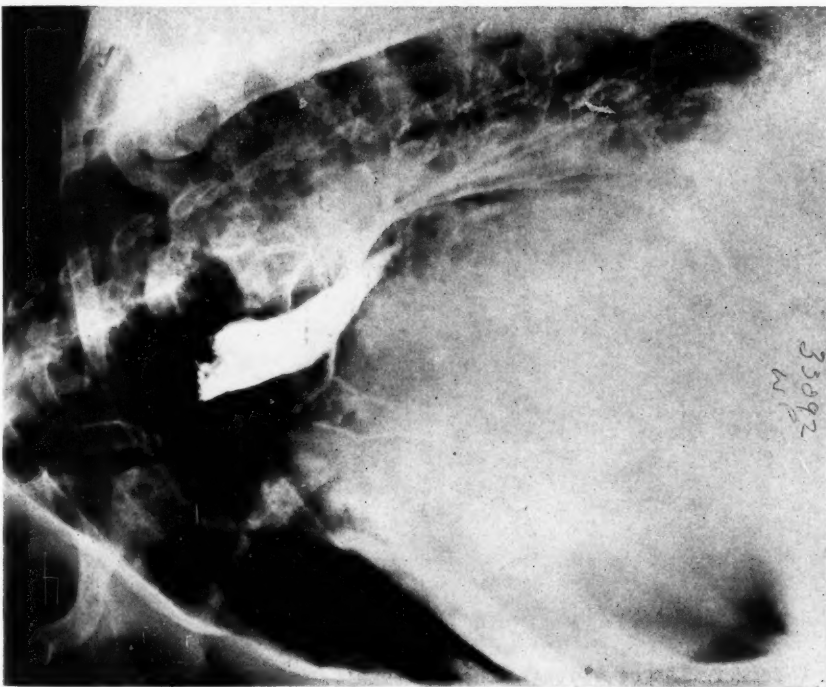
Case 3. Left anterior oblique radiograph showing that barium paste swallowed half an hour before the exposure still remains in the oesophagus, which is flattened by the enlarged left auricle. The left main bronchus, outlined by lipiodol, is displaced upwards by the left auricle
